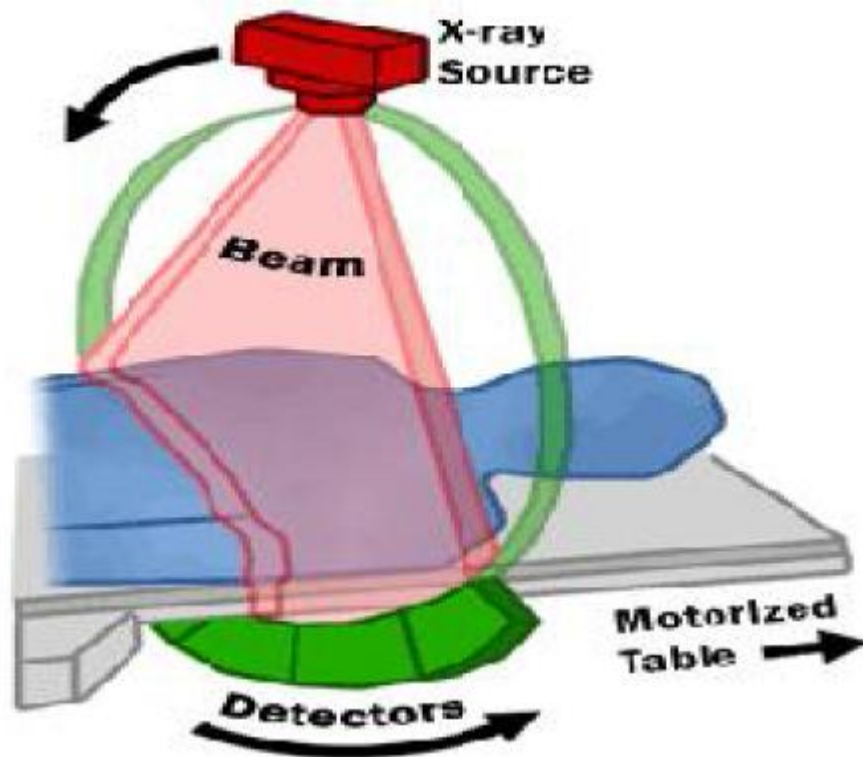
Simple overview of a third generation CT-imaging system
